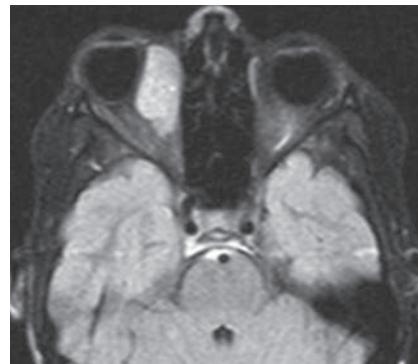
T1 MRI axial image post contrast demonstrating a right medial mildly lobulated orbital mass measuring 2.8 x 1.7 x 3.1 cm with diffuse enhancement post contrast.
